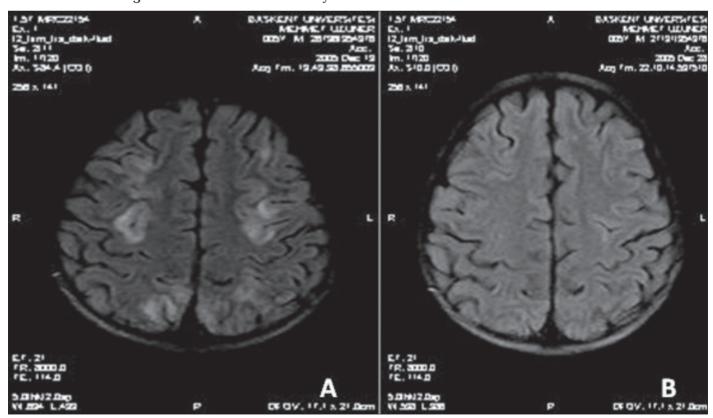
There are hyperintensities on both frontal and parietal white matter, consistent with vasogenic edema on initial axial FLAIR image (A). There are also similar signal changes in temporal lobes (not shown). On follow-up MRI, the FLAIR image shows regression of the edema at the frontal and parietal lobes (B)
